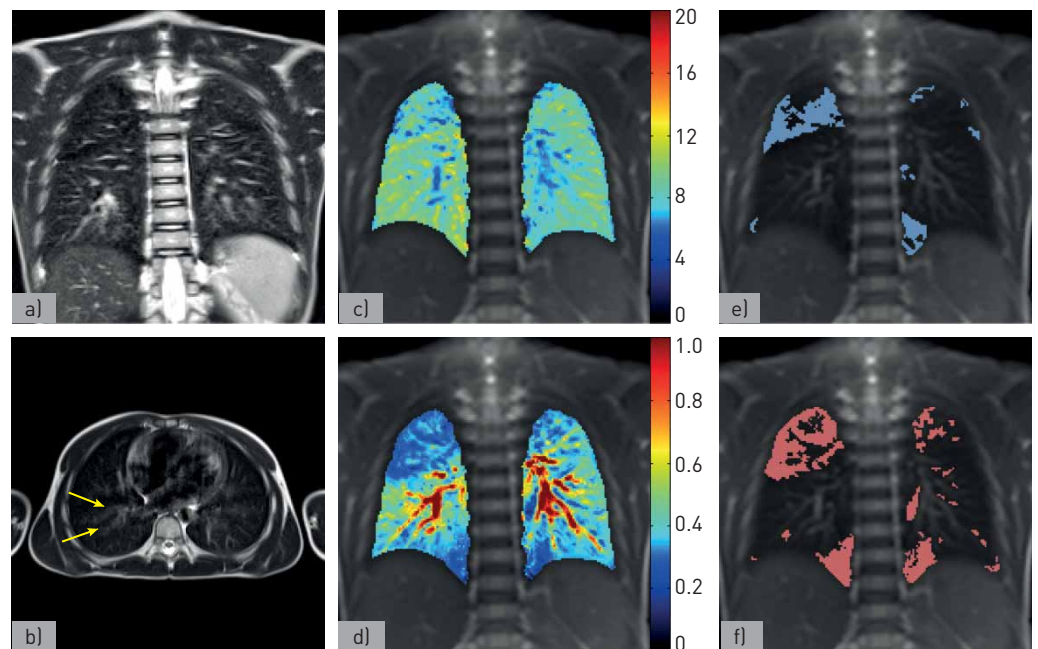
Example of a child with mild lung disease: a 9-year-old boy with cystic fibrosis. a) Coronal and b) axial 5-mm T2-weighted HASTE (half-Fourier acquisition single-shot turbo spin-echo) sequences. Mild bronchial wall thickening (b, arrows) is noted in the right lower lobe (Eichinger Score 1 (R1)). Otherwise normal chest magnetic resonance imaging (MRI). c) Functional MRI shows two main areas with reduced fractional ventilation located in the upper lobe of the right lung and basal part of the left lung. d) Relative perfusion map shows several regions with reduced perfusion in both lungs. e, f) Masks overlaid on morphological images present e) fractional ventilation defects (16% of the slice area) and f) perfusion defects (19% of the slice area). Lung clearance index was at the upper limit of normal (8.4 lung turnovers) and forced expiratory volume in 1 s was normal (0.46 z-scores).
